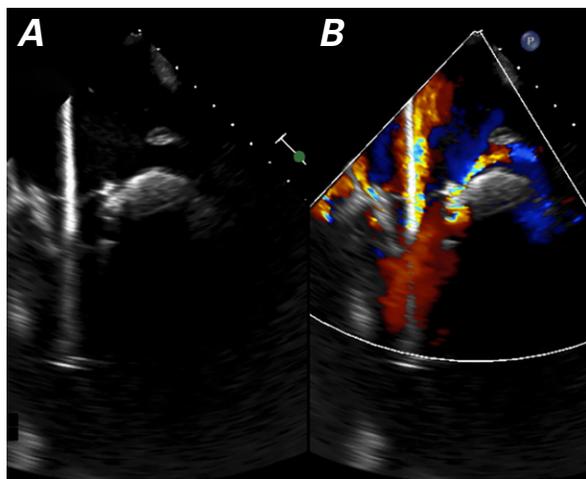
Transesophageal echocardiograms in A) 2-dimensional and B) color-flow Doppler modes and C) a fluoroscopic image at the time of valve deployment, obtained under rapid right ventricular pacing at the beginning of valve inflation, show the SAPIEN 3 valve in the mitral position in relationship to the native mitral annulus.
